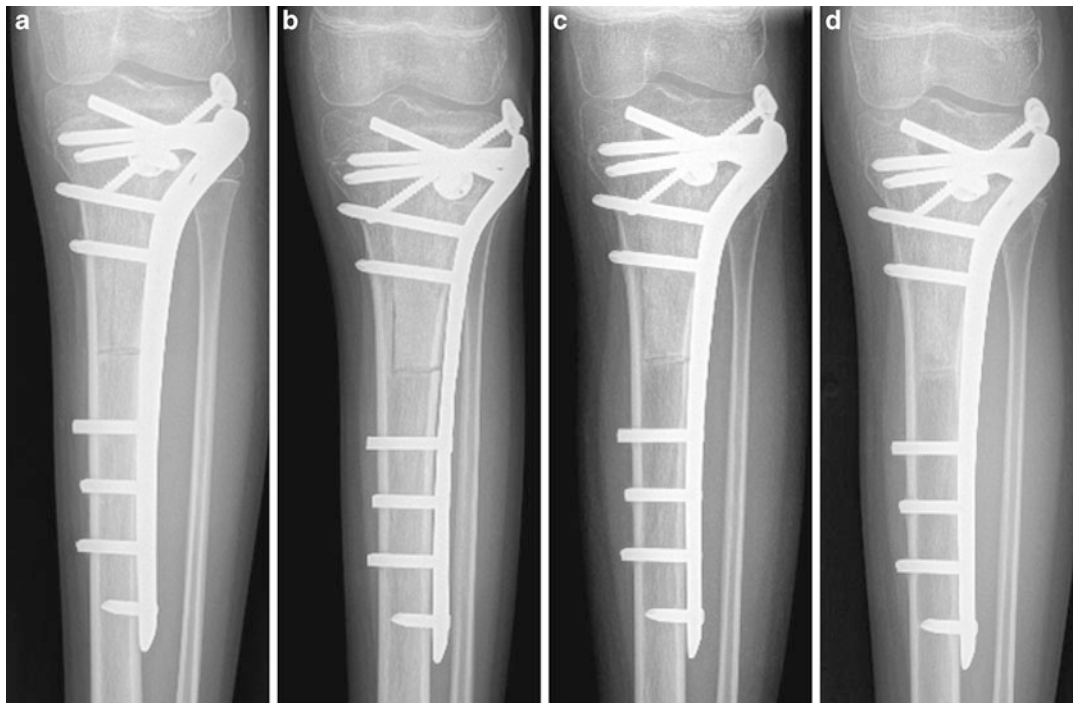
(a–d) Postoperative radiographs. (a) 1 month, (b) 3 months, (c) 6 months, (d) 12 months
